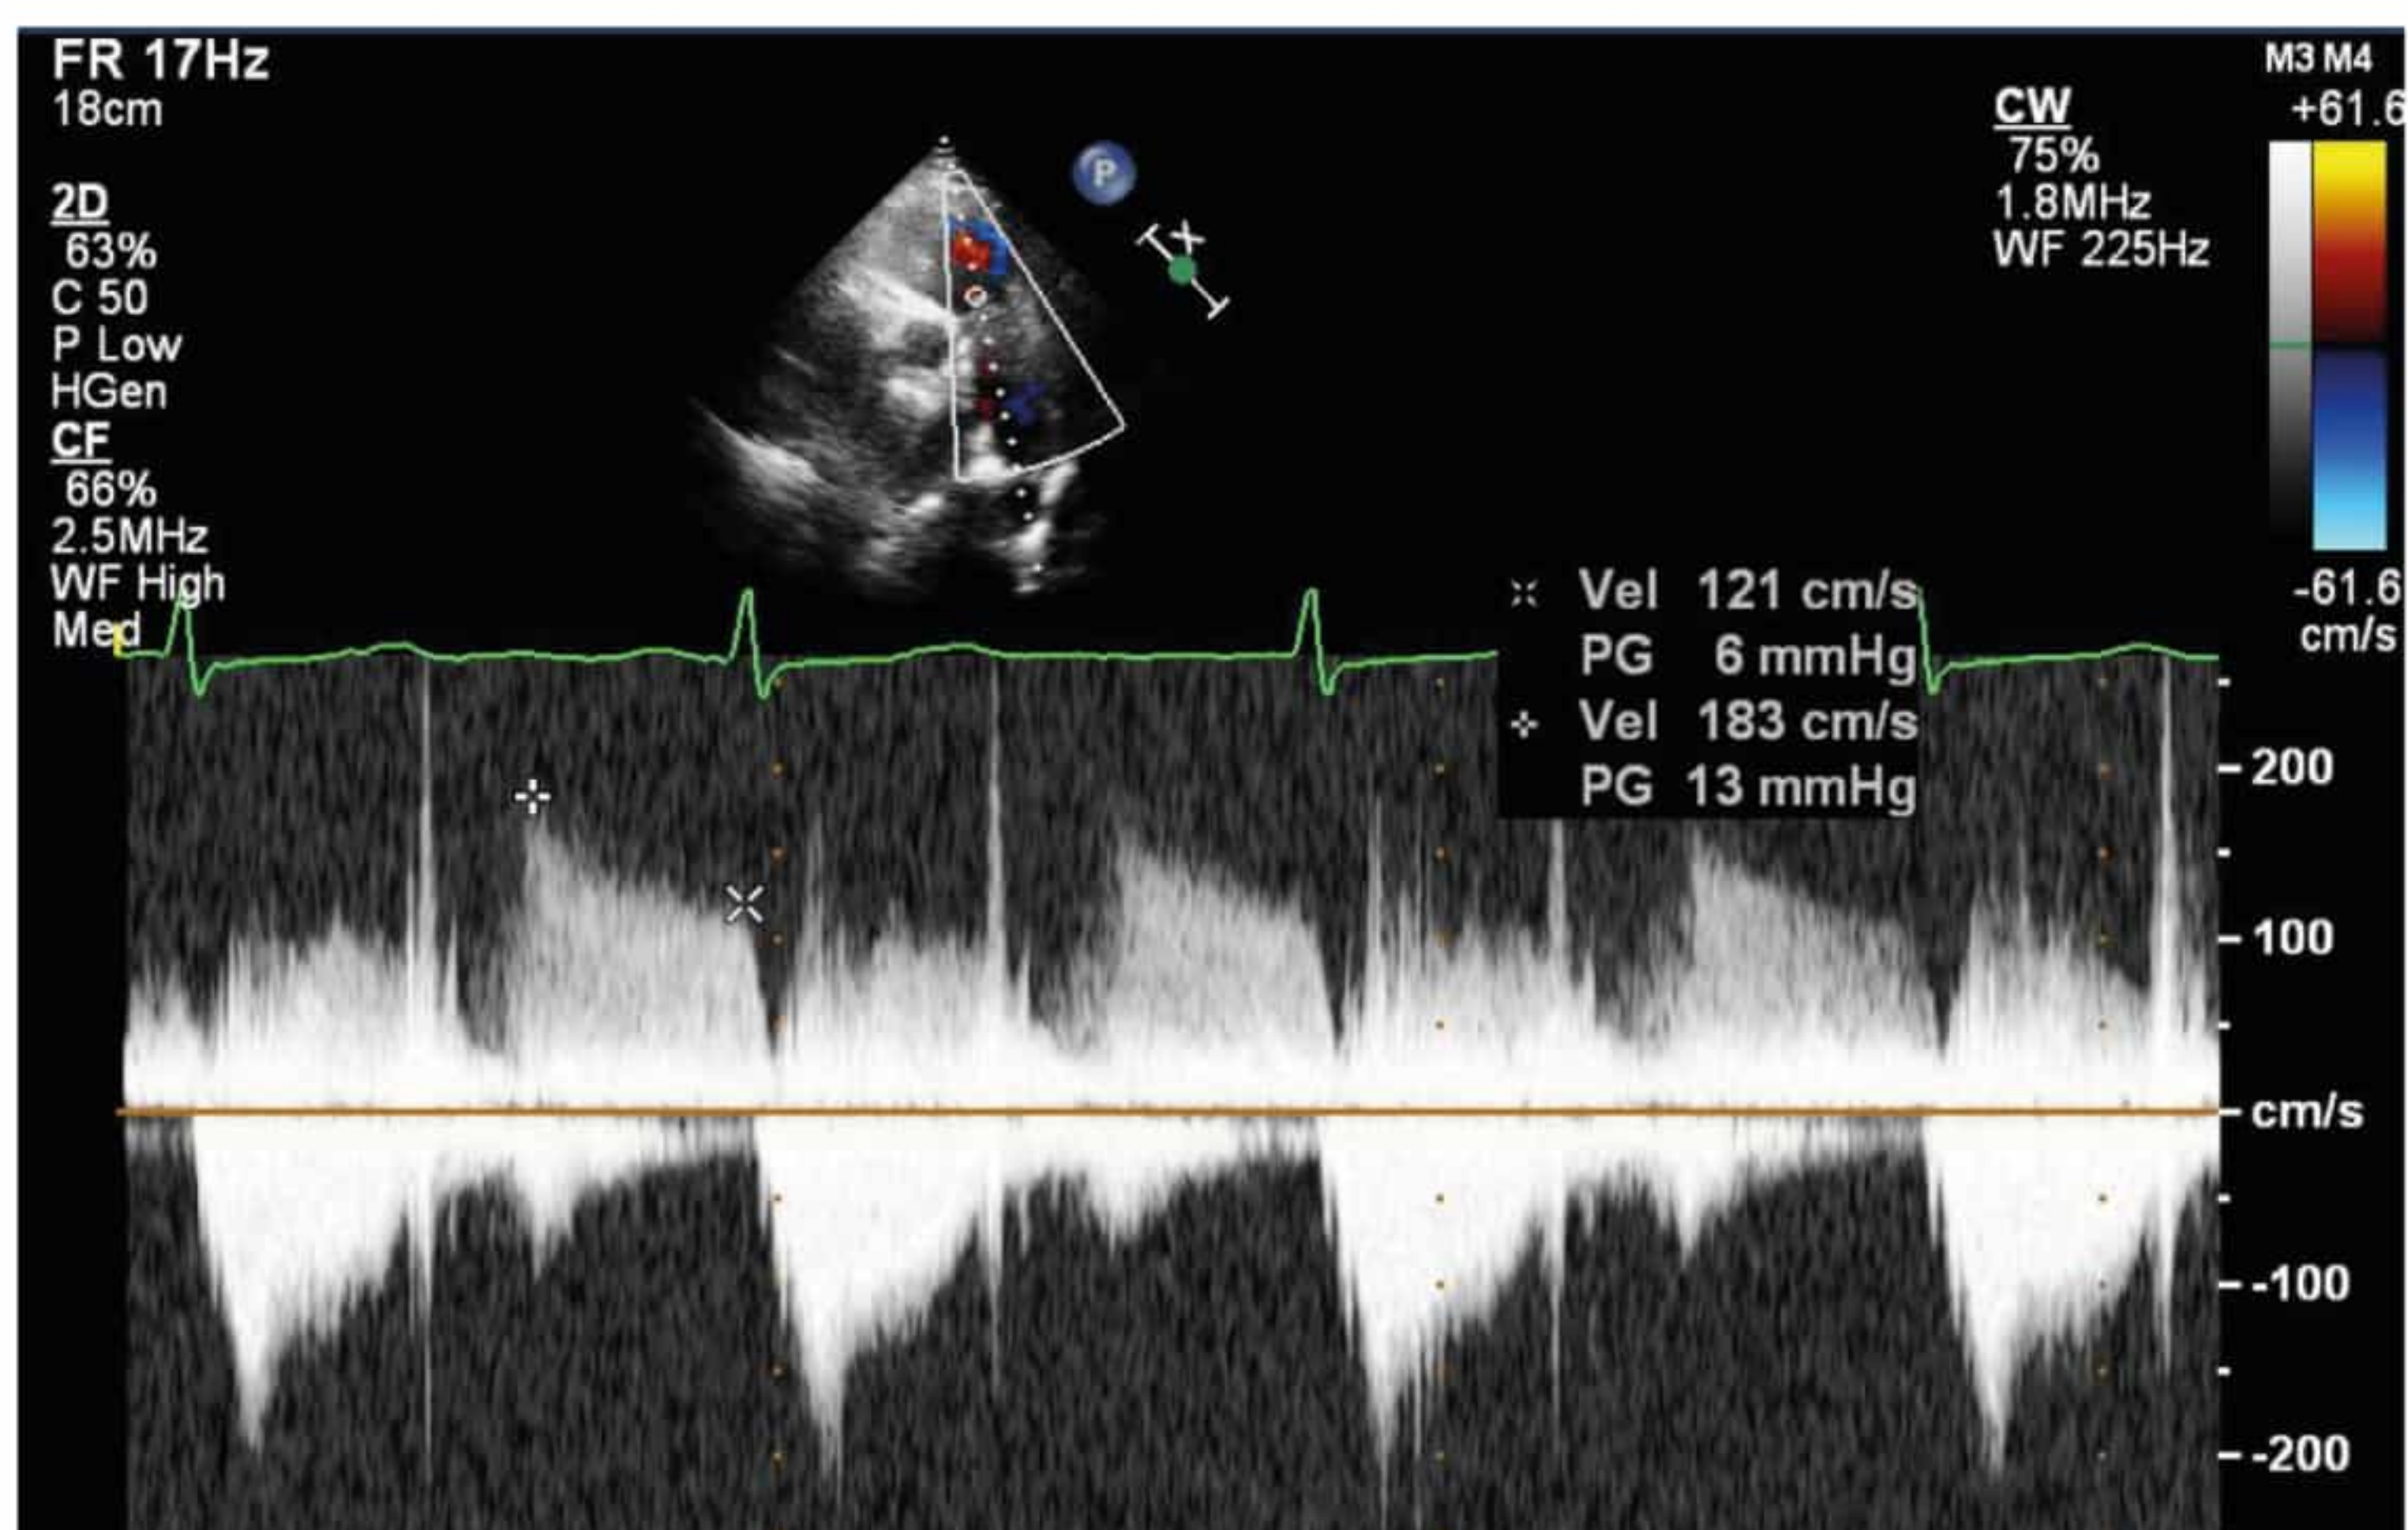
Doppler echocardiographic determination of pulmonary artery (PA) diastolic pressure (PADP) and mean PA pressure by continuous-wave Doppler signal of pulmonic regurgitation. Point 1 denotes the maximal pulmonary regurgitation (PR) velocity at the beginning of diastole. Mean PA pressure correlates with $4 \times (\text{peak PR velocity})^2 + \text{estimated RAP}$. In this example, PA mean pressure is 13 mmHg + right atrial pressure (RAP). Point 2 marks the PR velocity at end-diastole. PA diastolic pressure is correlated with $4 \times (\text{end PR velocity})^2 + \text{estimated RAP}$. In this example, PADP is 6 mmHg + RAP.
